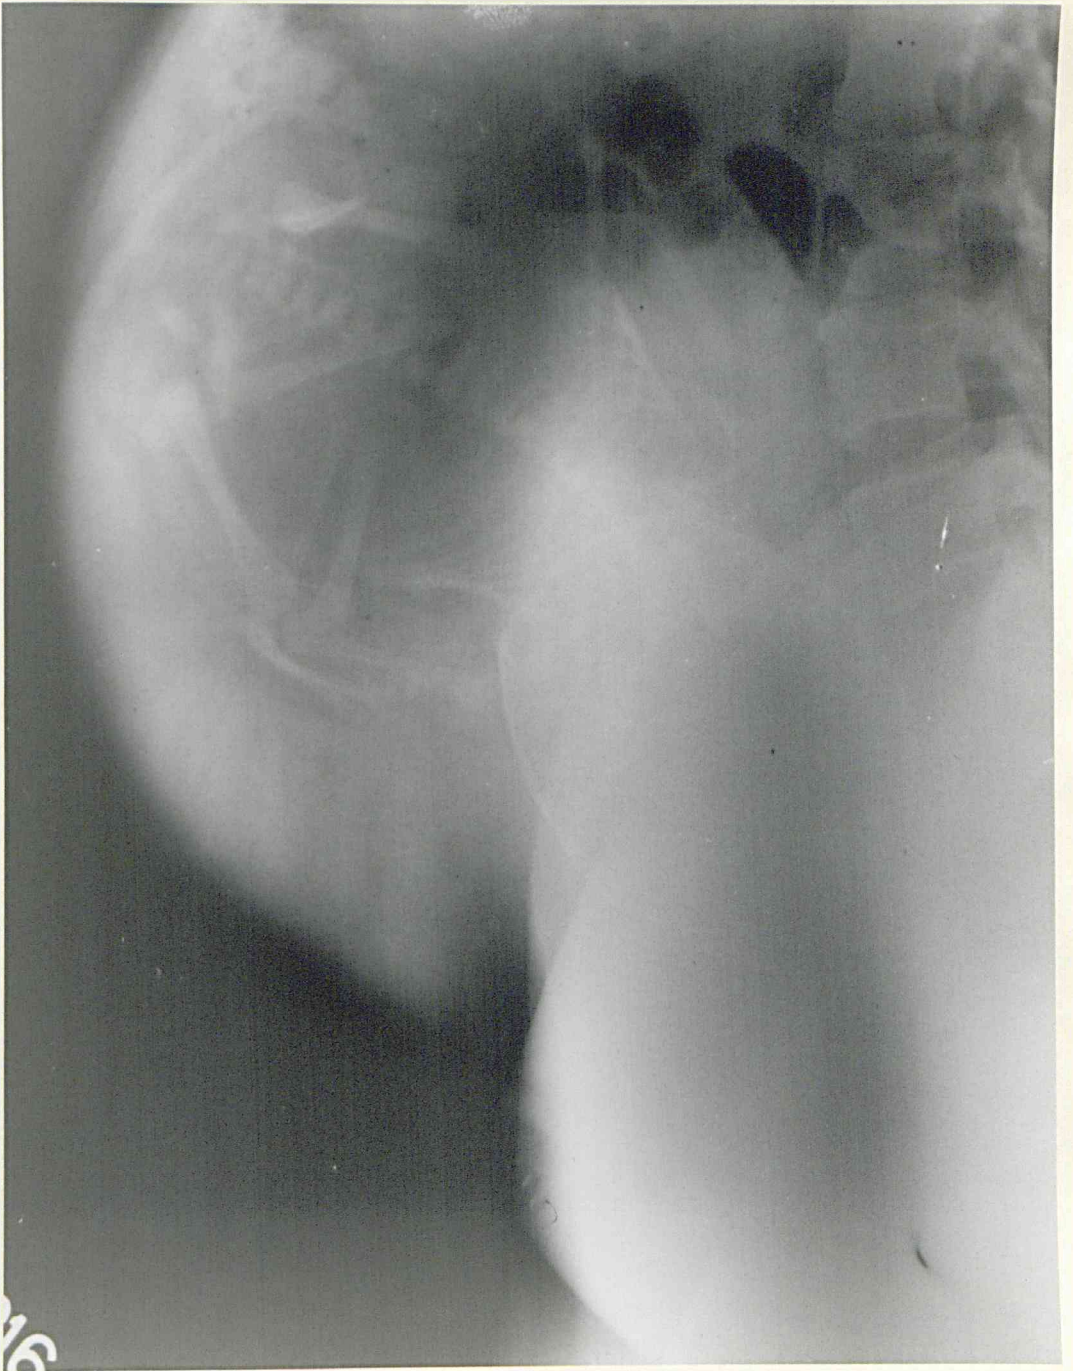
Lateral radiograph of the abdomen in a case of anterior placenta praevia. The "placental shadow" is shown to be very low on the anterior uterine wall. (Case No. 242).
